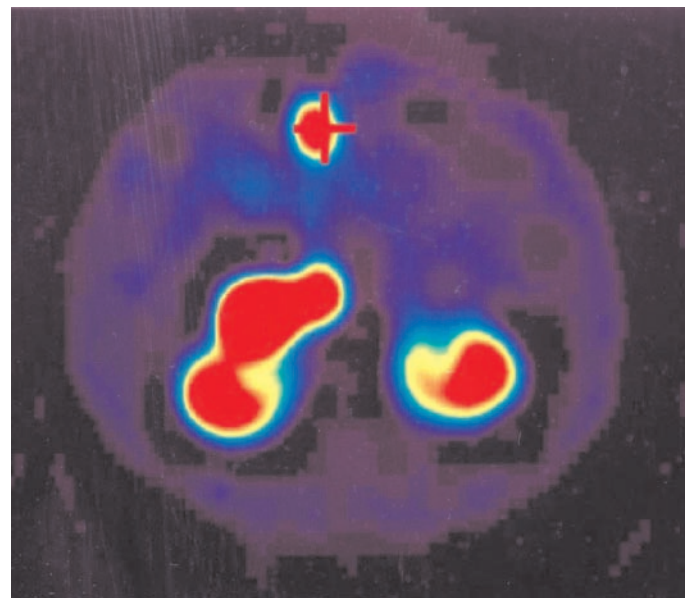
Imaging of a patient with a malignant insulinoma who received a therapeutic dose of ^{90}Y -trium-octreotide (OctreoTher); the primary lesion in the head of the pancreas is clearly demonstrated in the SPECT reconstruction (marked with a *cross*) (courtesy of Dr. K. E. Britton, Department of Nuclear Medicine, St. Bartholomew's Hospital, London, UK).
